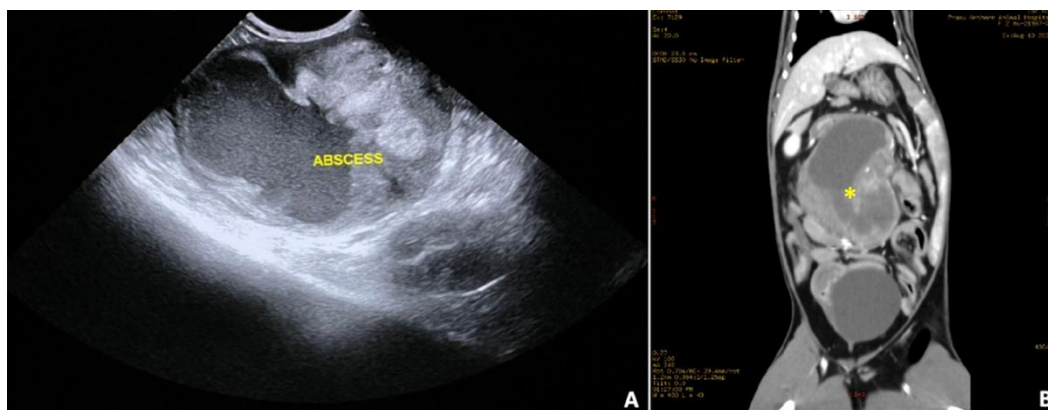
(A-B) Abdominal ultrasonographic examination (A) and CT scan (B) revealed an intestinal mass at the ileocecolic junction (yellow asterisk).
